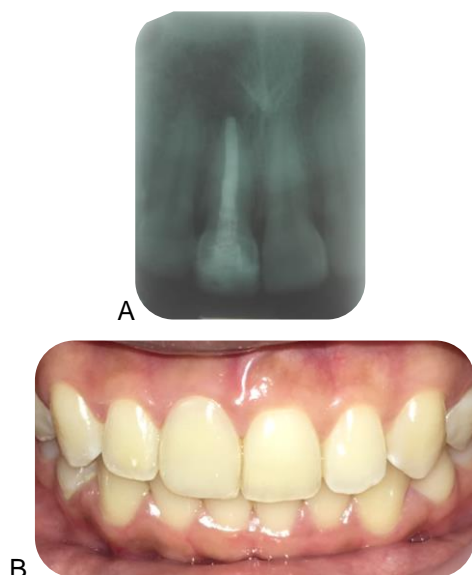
A) Radiographic appearance of the tooth indicates a radiolucent area in the apical section with a diameter of approximately 1 mm. The edge of the lift is in good condition. B) Clinical features of the lift 11 during the control session indicated
